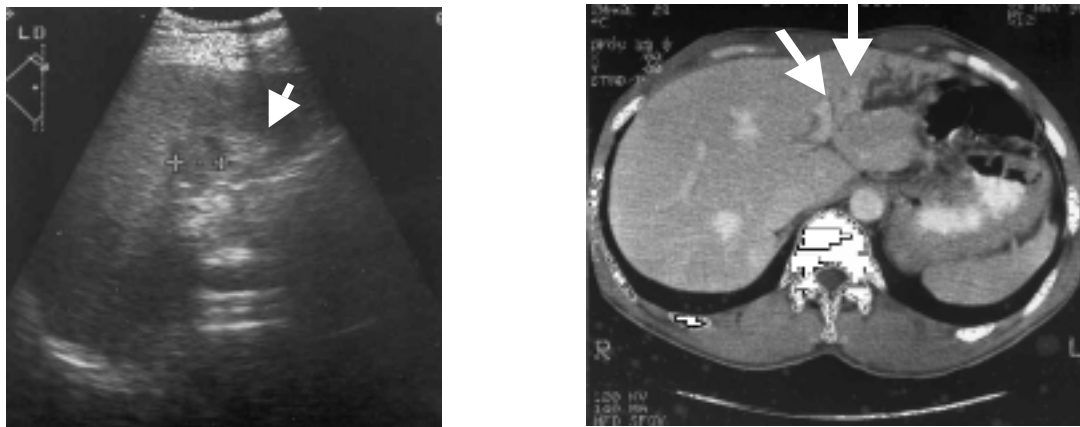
a) U/S of a Suspected CHCA Case Shows a Characteristic Mass in Segment 3 of the Liver (arrow). b) CT of the Same Subject Confirms the Mass and Dilated Intrahepatic Ducts (double arrows).
